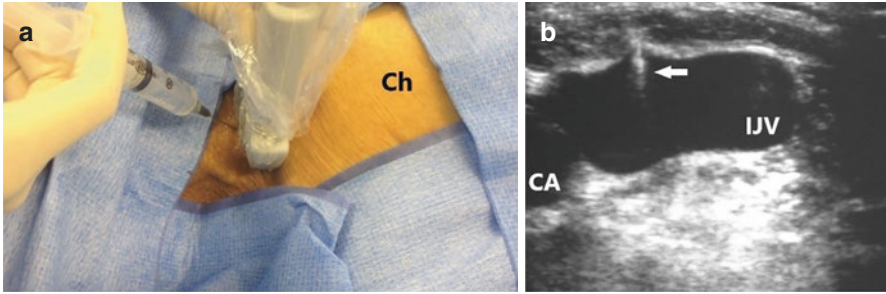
Anterior puncture of the internal jugular vein. (a) Ch—patient's chest; (b) corresponding ultrasound image; CA—carotid artery; IJV—internal jugular vein; white arrow—puncture needle
